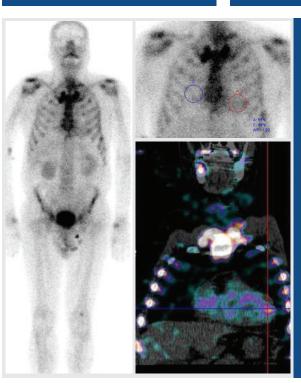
Light chain amyloidosis. Whole body and anterior bone 99mTc-Pyrophosphate scintigraphy showing mild uptake in myocardium; heart/ contralateral uptake reveals 1.13; c) SPECT/CT coronal image show regional area of increased activity in apex.
